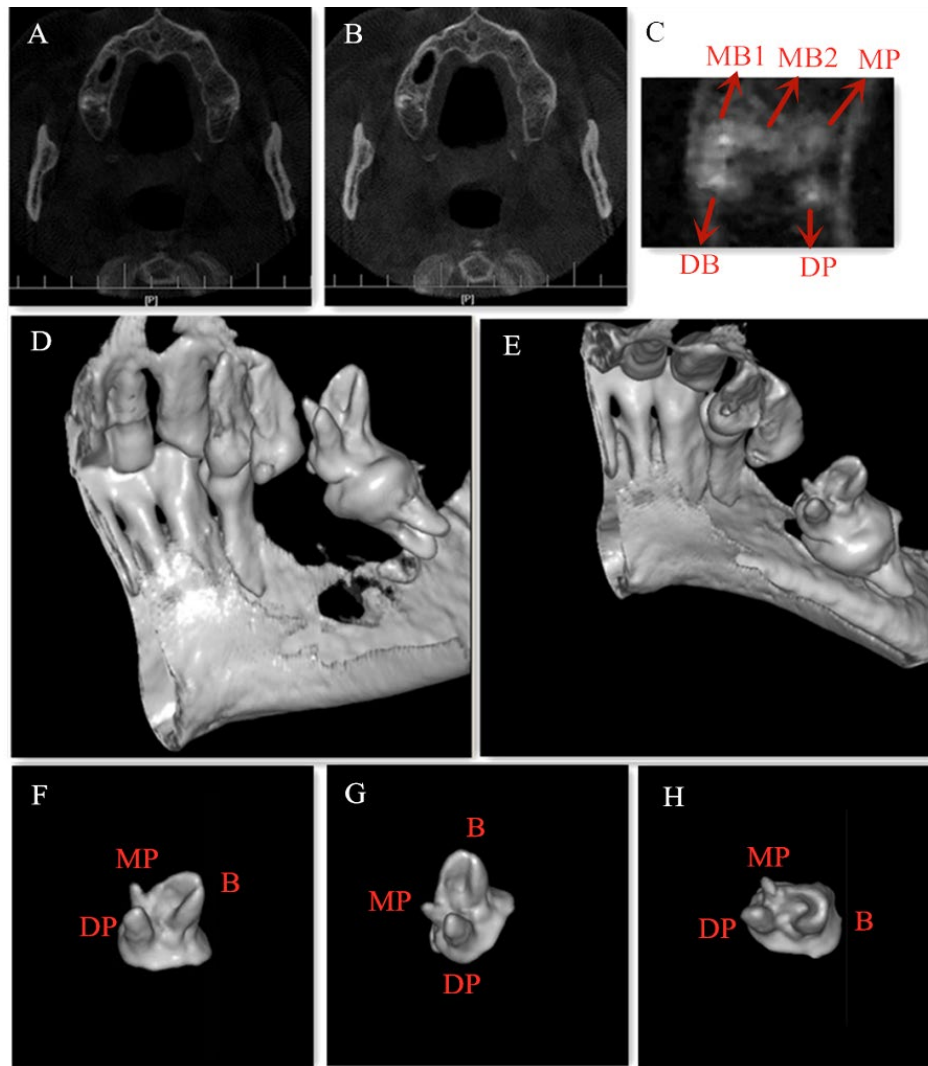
CBCT scanning images and 3D reconstruction of tooth #17. A and B) The different CBCT scanning levels of tooth #17; C) An enlarged picture of tooth #17 showing five canals: MB1, MB2, DB, MP and DP; D-H) The 3D reconstruction of tooth #17 showing three roots: one C-shaped buccal root, one MP root and one DP root
